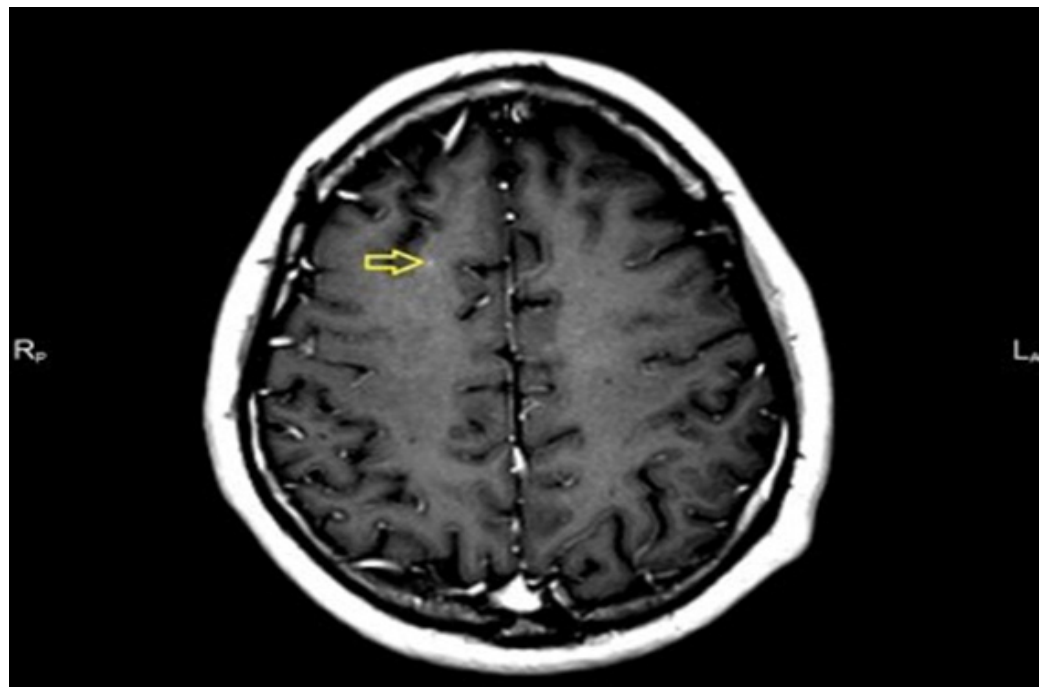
Axial T1-weighted MRI with gadolinium contrast enhancement. The image shows an enhancing lesion (indicated by the yellow arrow) located in the right frontal lobe, adjacent to the central sulcus.
